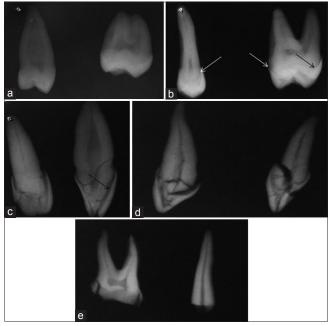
Radiographic appearance (a) 200°C: No changes (b) 400°C: Gapping along DEJ and CEJ (c) 600°C: Complete separation of hard tissues at DEJ and CEJ (d) 800°C: Many fracture lines throughout crown and root (e) 1000°C: Complete disintegration of crown
